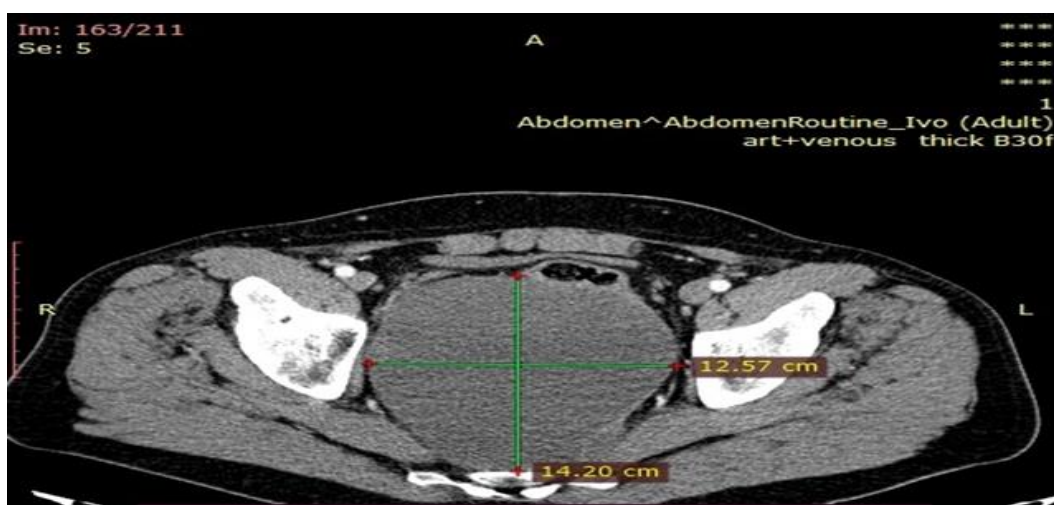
Axial image of the tumor on CT
